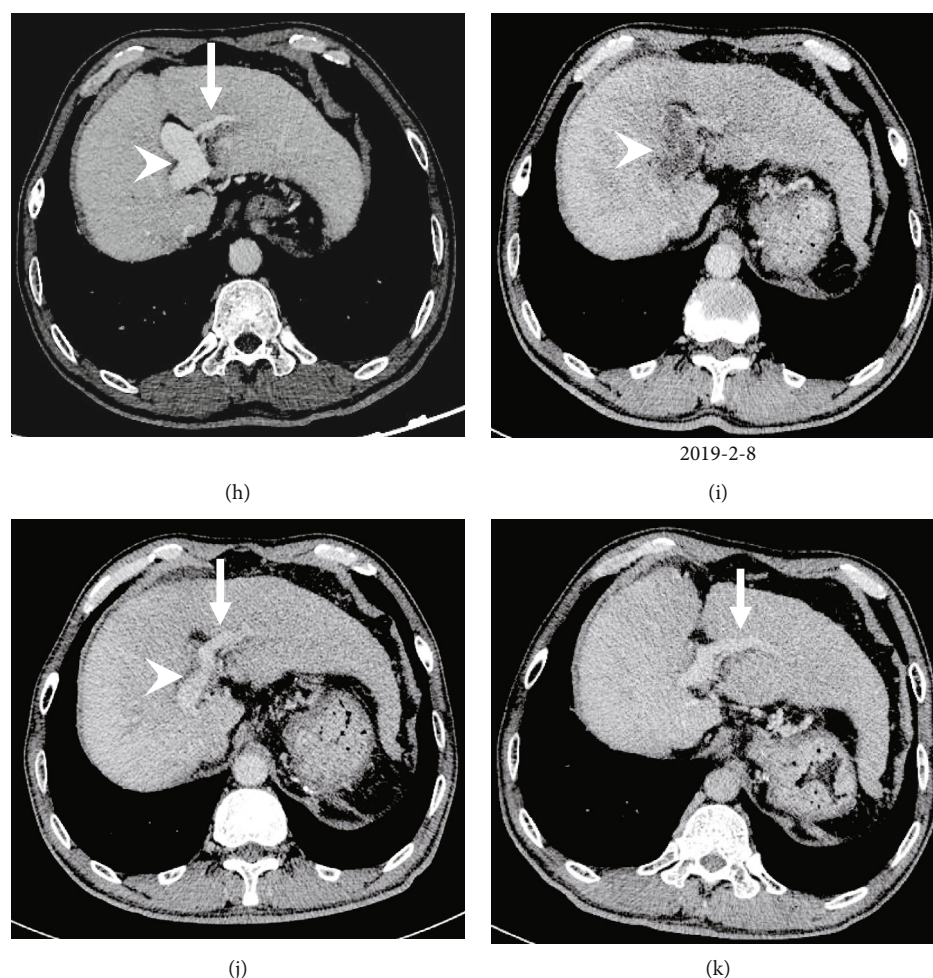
Images in a 54-year-old male diagnosed with type II CEPS with HE who underwent endovascular embolization. (a) Anteroposterior VR image reconstructed from CTA data prior to occlusion shows portal vein and its fine intrahepatic branches (green), IVC (blue), and tortuous and dilated portal vein-iliac vein shunt via the paraumbilical vein (red). (b) Sagittal VR image shows portal vein and its branches (green) IVC (blue) and the shunt (red). (c) Sagittal maximum intensity projection at the portal venous phase demonstrates the portal vein, IVC, and the shunt, in accordance with the VR findings. (d) Indirect portal venography via SMA demonstrates portal venous outflow drained into a tortuous and dilated shunt (black arrow). (e) Portal venography demonstrates partial hypoplastic intrahepatic portal venous veins (white arrow) and the communication between the portal vein and right iliac vein (dotted arrow) via the shunt (black arrow). (f) Portal venography with balloon occlusion shows hypoplastic intrahepatic portal veins (white arrow). The PVP is 21.7 and 24.3 mmHg before and 15 min after balloon occlusion, respectively. (g) The shunt was embolized with Amplatzer plug (curved arrow). (h) Preoperative contrast-enhanced CT image demonstrates the dilated main portal vein (arrowhead) and the hypoplastic intrahepatic portal vein branches (white arrow). (i) CT scan shows portal vein thrombosis (arrowhead) at 1 month after the procedure which disappeared after seven-day anticoagulation therapy. (j) Contrast-enhanced CT images demonstrate the main portal vein shrinking into normal level (arrowhead), and the intrahepatic portal veins (white arrow) grow well at 12 months after interventional occlusion. (k) CT scan demonstrates that the intrahepatic portal veins (white arrow) grow well at 36 months after the procedure.
